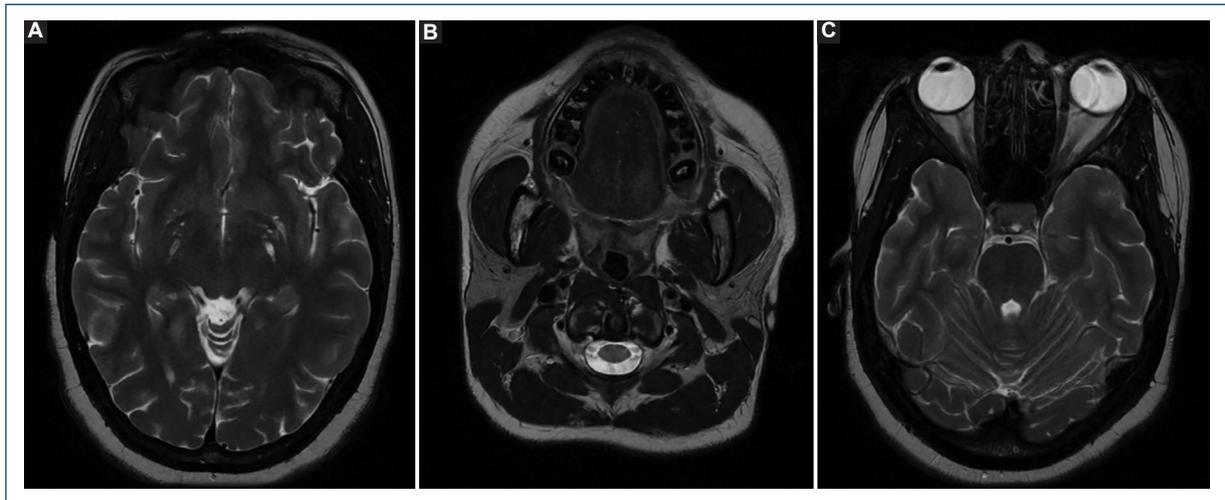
Head magnetic resonance imaging. Atrophy of the skin and underlying soft tissue with fat paucity on the right frontoparietal (A), and mental regions (B), and mild right enophthalmos (C).
